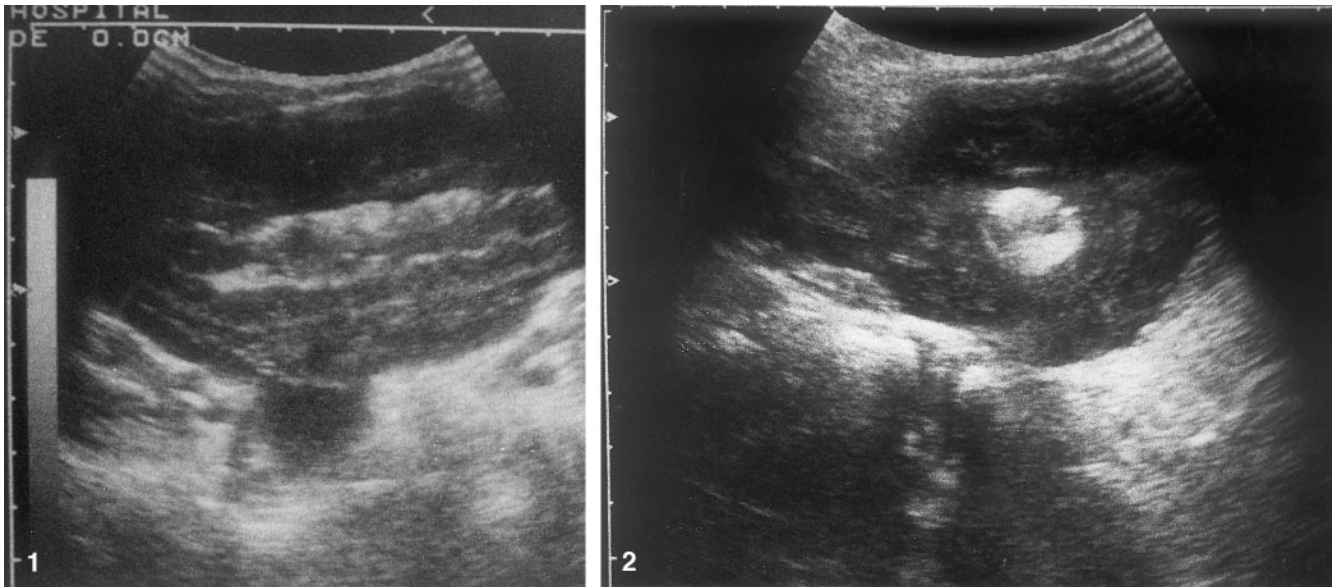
Ultrasound scan of abdominal tumor: longitudinal section shows several layers with thickened high- and low-level echoes
